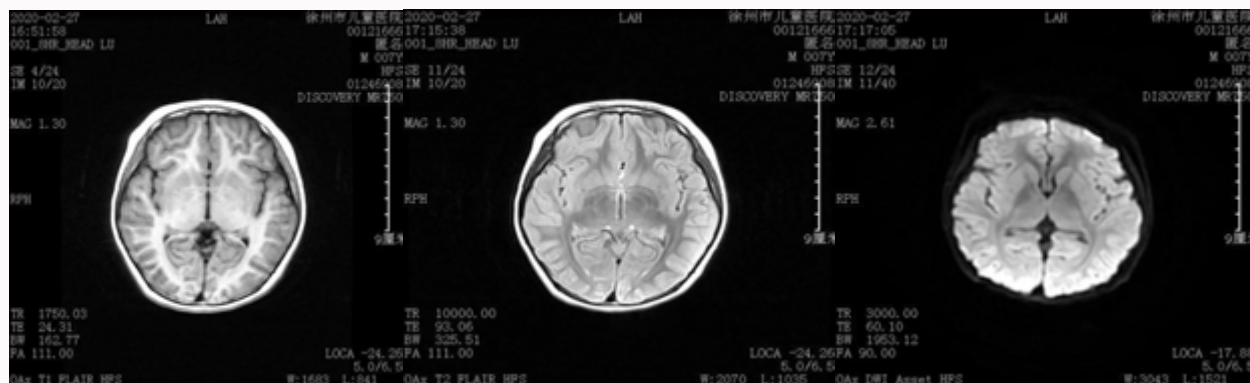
Brain MRI showed no abnormality before treatment.
